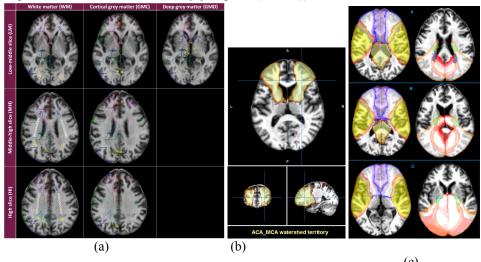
Templates (a) Object map of the ROIs and arterial territories on a fast spoiled gradient echo (flip angle 12°) (fspgr12) (b) Example of a probabilistic map of arterial territory; (c) Representative slices of the probabilistic map of all arterial territories, including watershed regions, on a T1-weighted image.
